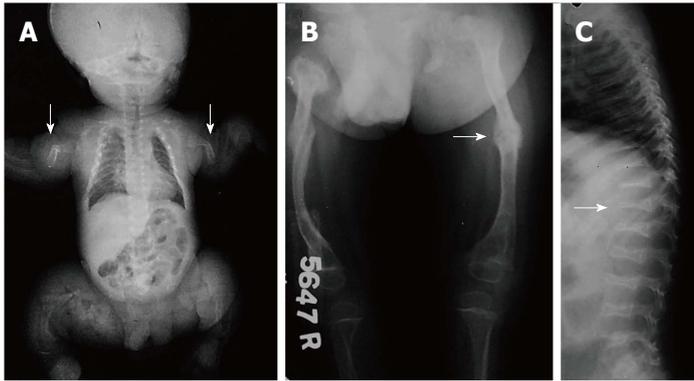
Osteogenesis Imperfecta. Infantogram of 1-mo baby shows diffuse osteopenia with multiple fractures in extremities (arrow). Radiograph of another patient shows fractures in bilateral femurs with callus formation (arrow). Radiograph of spine (C) shows osteopenia with codfish vertebrae.
